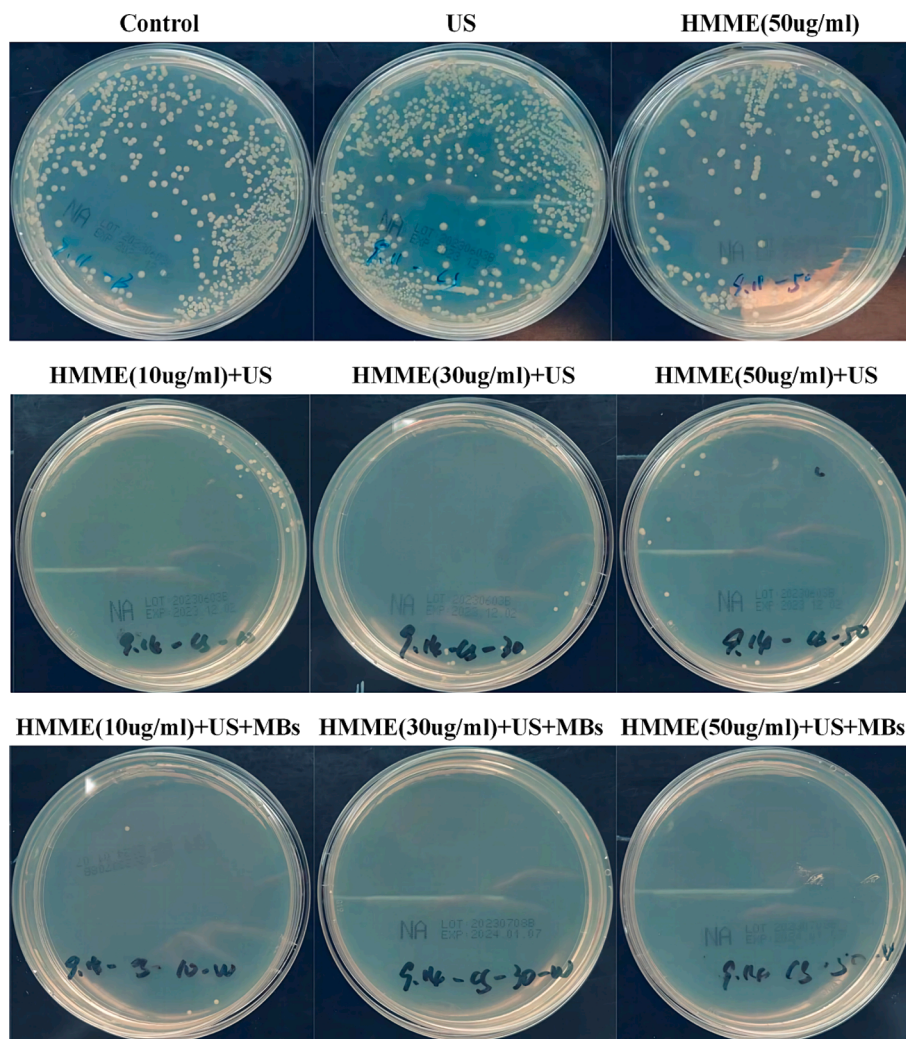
The growth of bacteria under different conditions in agar solid media for 12 h. (a) Inhibition of *Escherichia coli* with ultrasound only and with HMME at 50ug/ml only compared to the control group; (b) The inhibitory effect of SDT on *Escherichia coli* at various concentrations of HMME; (c) The inhibitory effect of SDT with MBs on *Escherichia coli* at various concentrations of HMME.
